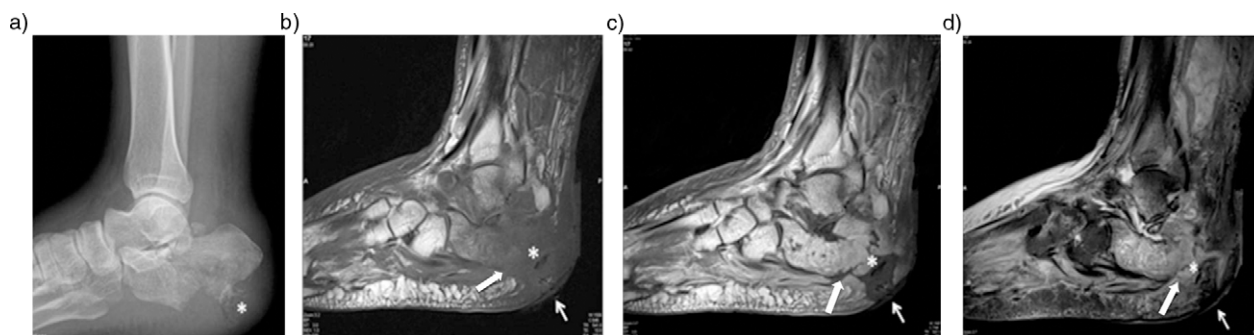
A 57-year-old diabetic patient with long-standing neuropathic arthropathy. Plain radiograph shows hindfoot deformity and calcaneal fragmentation due to Charcot disease (a). T1-weighted sagittal pre (b) and post-contrast (c) and T2-weighted fat-suppressed (d) images reveal skin ulcer and associated a wide sinus tract formation (arrow) containing free air (asterisks), extending to bony cortex. Note the replacement of soft tissue fat (solid white arrow); subcutaneous and periarticular enhancement and osseous contrast enhancement that is consistent with infected neuroarthropathy.
